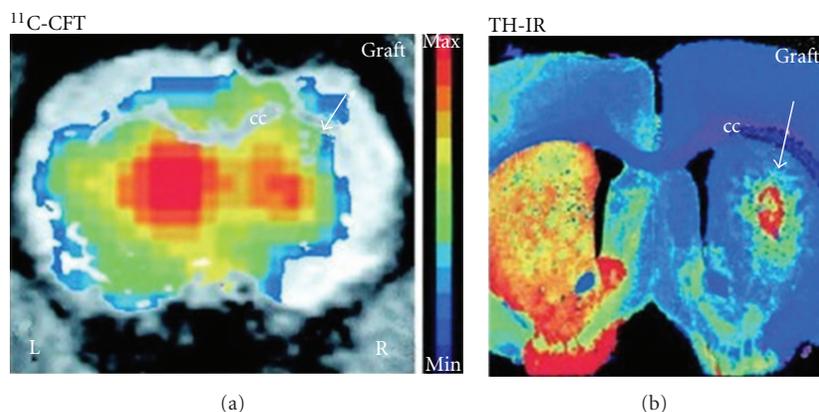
The specific dopamine transporter (DAT) ligand [ $^{11}\text{C}$ ] CFT binding in the right grafted striatum was detected using PET, as shown in this brain slice (a). Increased [ $^{11}\text{C}$ ] CFT binding was found in the right striatum, which may correlate with the postmortem presence of TH-immunoreactive (IR) neurons in the graft (b). Color-coded (activity) PET images were overlaid with MRI images for anatomical localization [37].
